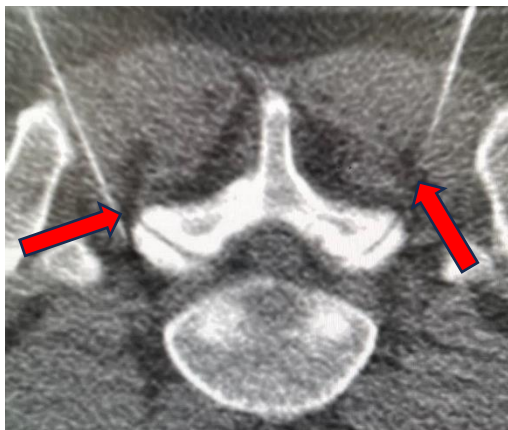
CT scan check of correct needle placement (arrows).
